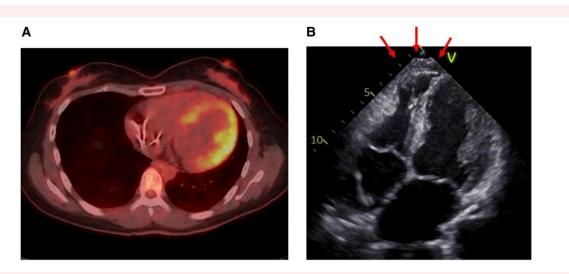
¹⁸F-fluorodeoxyglucose positron emission tomography and transthoracic echocardiography. (A) ¹⁸F-fluorodeoxyglucose positron emission tomography showed abnormal uptake and (B) the right ventricular apex showed with the ventricular aneurysm.
